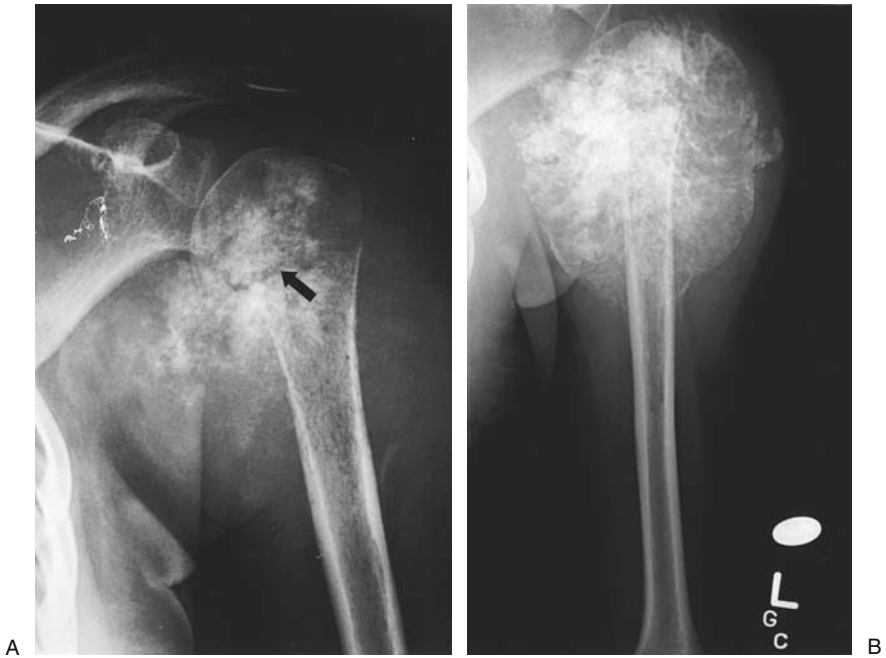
Osteosarcoma. (A) AP radiograph of the left proximal humerus shows a large expansile, lytic osteosarcoma with marked bony destruction. The *arrow* indicates a pathologic fracture, and there is clear evidence of a soft tissue component in the medial tissues; 95% of bone sarcomas have a soft tissue component. (B) AP radiograph shows a large osteosarcoma of the proximal humerus following induction chemotherapy. Healing of pathologic fractures and ossification of the tumor following use of chemotherapy are good prognostic signs. There is substantial ossification of this lesion.
